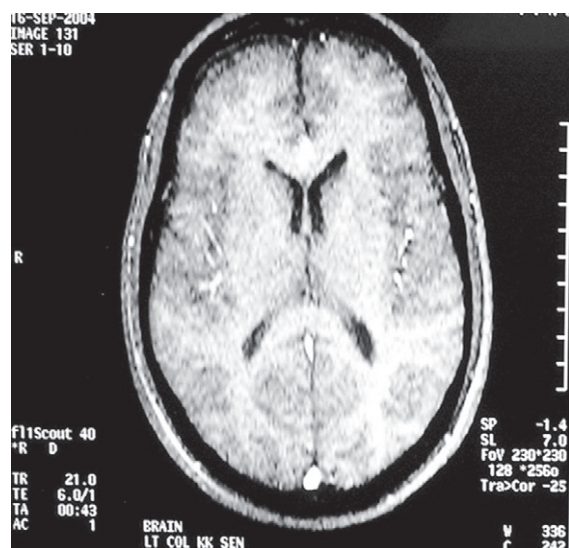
MRI (T1 axial) showing thrombus in superior sagittal sinus
